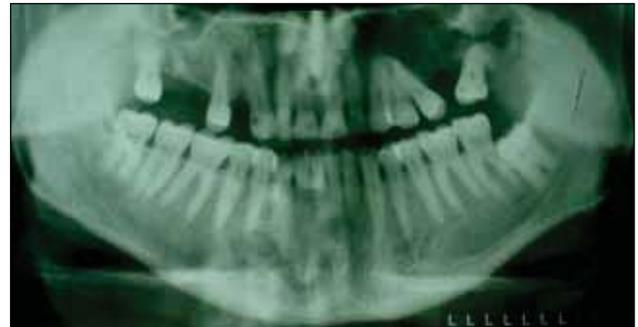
Orthopantomogram before operative procedure in maxilla*
